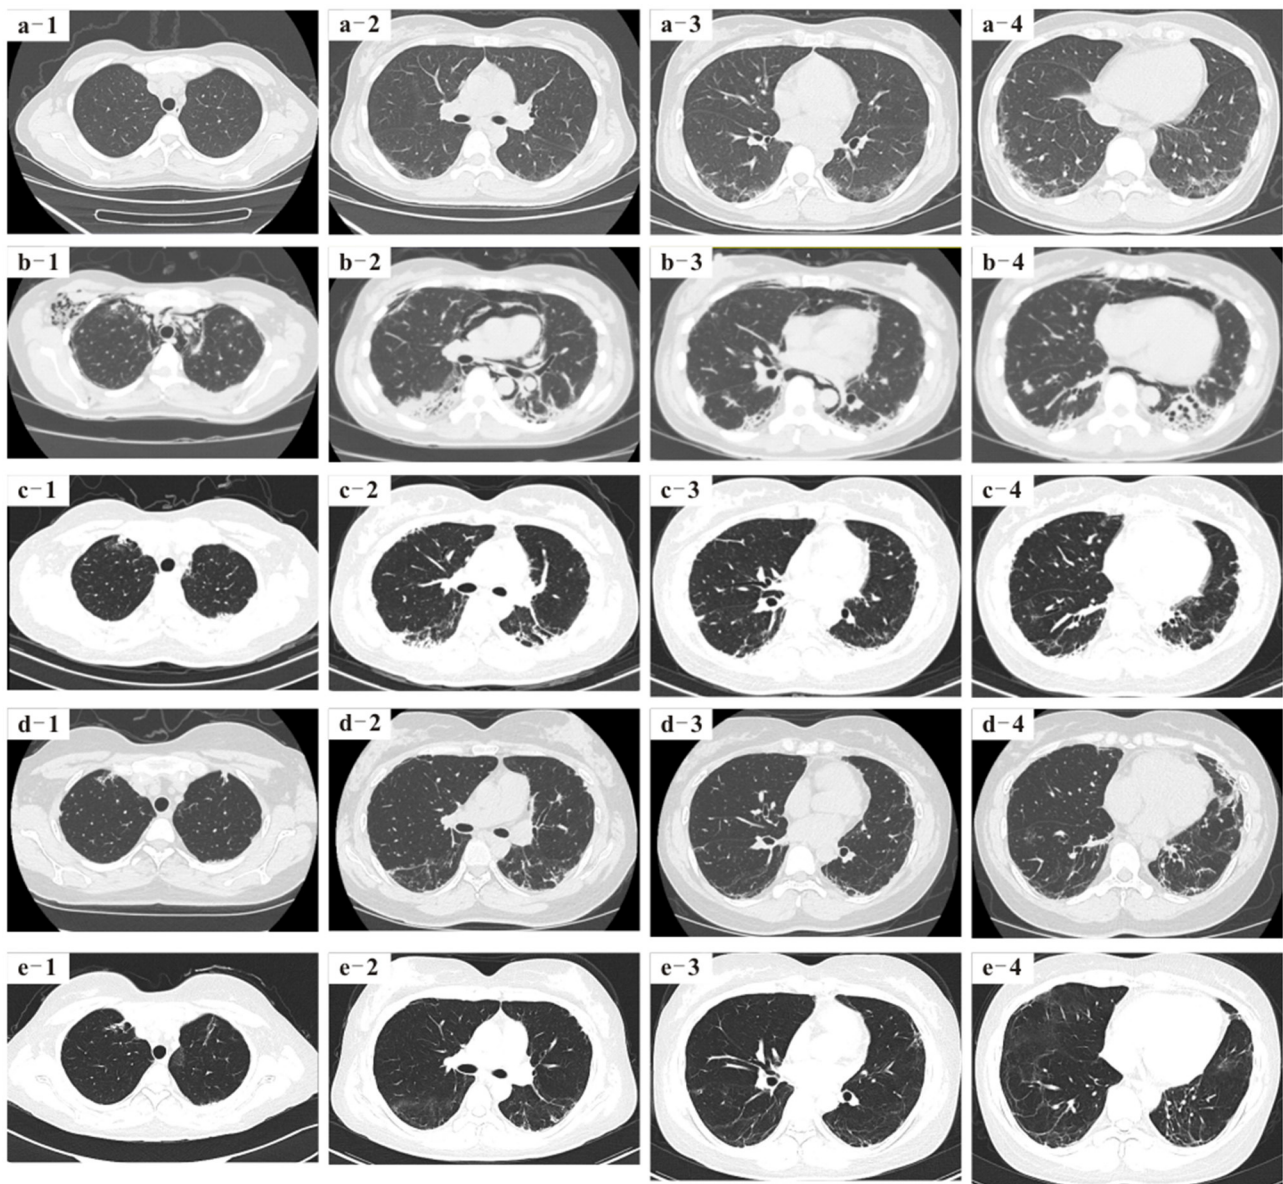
(a1–a4) Pulmonary high-resolution CT (HRCT) 4 months before baseline showed interstitial inflammatory changes in the lungs. (b1–b4) Pulmonary HRCT of baseline showed that the pulmonary interstitial inflammatory changes were more serious than before, mediastinal and subcutaneous emphysema appeared, and diffuse ground-glass shadows were seen in both lung fields. (c1–c4) Pulmonary HRCT reexamination on 4 months after the patient was discharged from our hospital showed that the diffused ground-glass shadows were less than those on March 2018, and mediastinal and subcutaneous emphysema were significantly absorbed. (d1–d4) Pulmonary HRCT on 9 months after the patient was discharged from our hospital showed that the lungs were much better than on March 2018. (e1–e4) More than 2 years later after the patient was discharged from our hospital, pulmonary HRCT showed lesser ground-glass shadows, and her lungs were much better than before.
